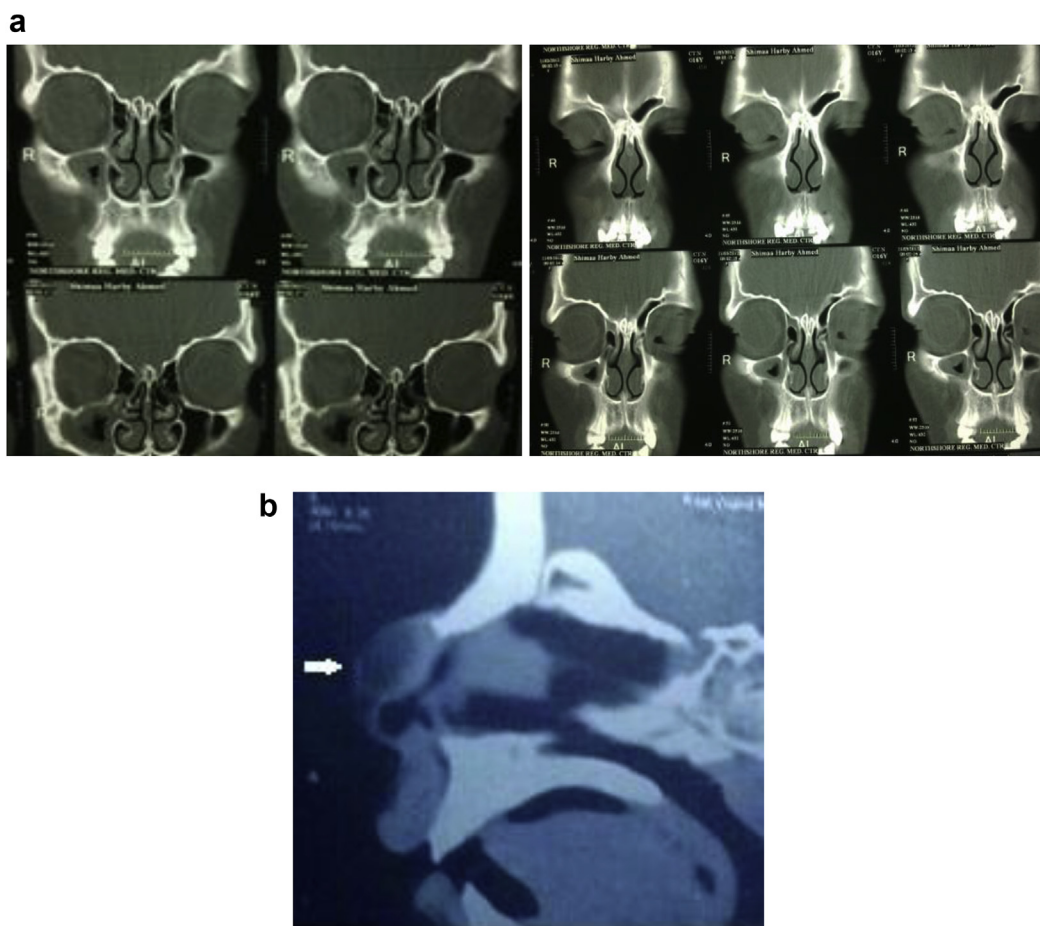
(a) Coronal CT scans showing a bifid crista galli in a 16-year-old female suspected to have an intracranial extension. (b) Sagittal CT Scan showing the cyst on the dorsum.
